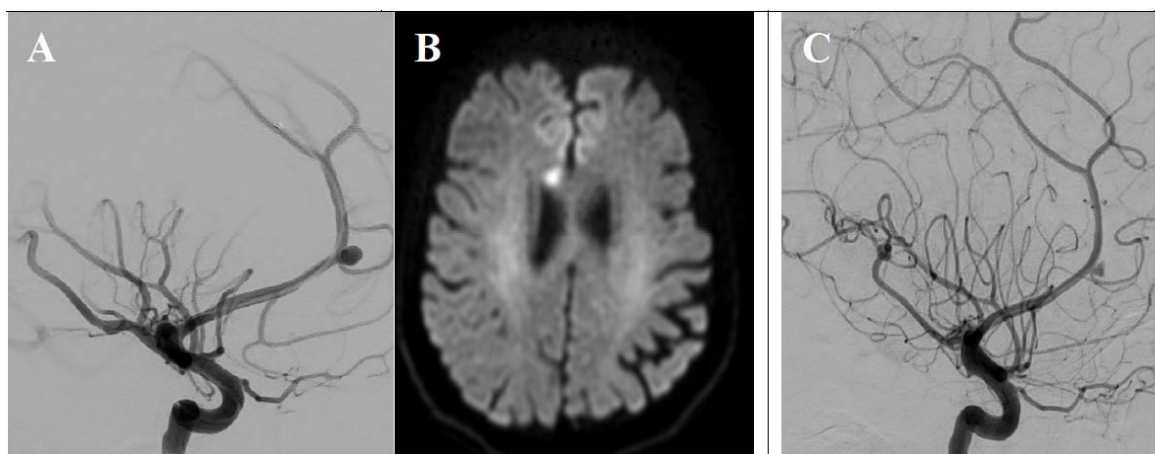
Imaging and long-term follow-up of a right pericallosal aneurysm with associated frontal infarct. (A) DSA of the right ICA in the WP showing a right pericallosal aneurysm. (B) Diffusion-weighted MRI revealing a small right frontal paramedian infarct corresponding to left lower limb monoparesis. (C) Eighteen-month follow-up DSA in the same projection demonstrating near-complete occlusion with a minimal residual remnant of the aneurysm.
